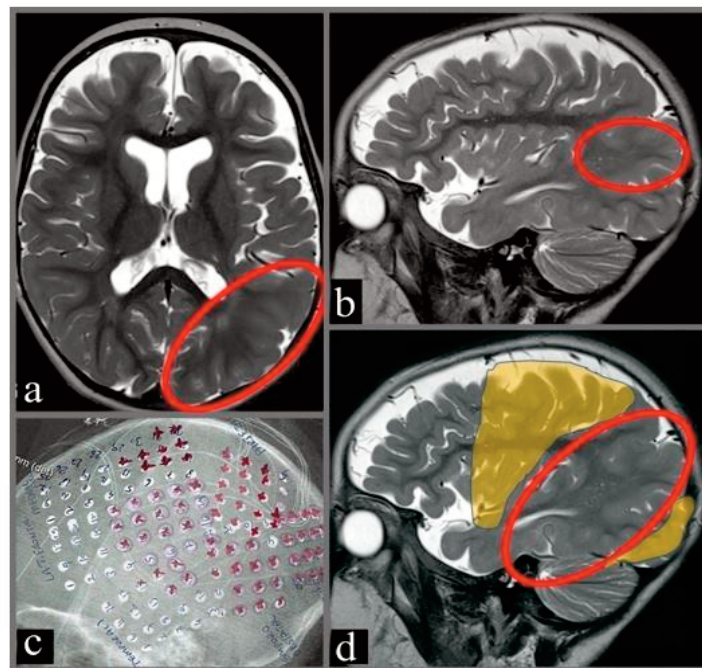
Patient with refractory epilepsy. a: Axial T2 MRI sequence showing the signal abnormalities in the left parietal and occipital hemisphere (red circle). b: Sagittal T2 weighted images showing the same appearance. (red circle). c: Lateral skull X rays of subdural grid insertion for electric activity monitoring .d: Yellow field plus red circle designates the subdural grid proven epileptic foci. Red circle indicates the area that we decided to remove before we performed invasive grid monitoring. Yellow area indicates the abnormal epileptic foci that we would skip if we did not perform invasive grid before resective surgery.
